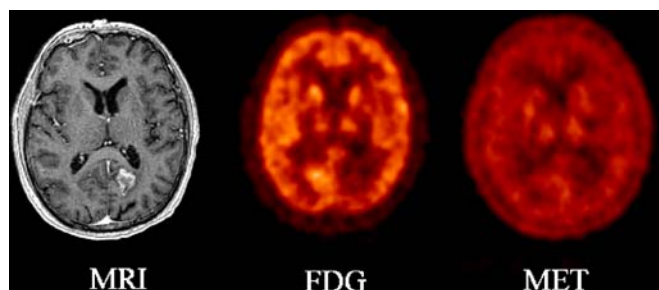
Radionecrosis. Status grade III astrocytoma in left parieto-occipital region, post-surgery and post-radiotherapy recurrence of symptoms after 6 months of last treatment. MRI clearly shows the lesion in the same area; however, both FDG and methionine show no uptake consistent with the diagnosis of radiation-induced necrosis.
